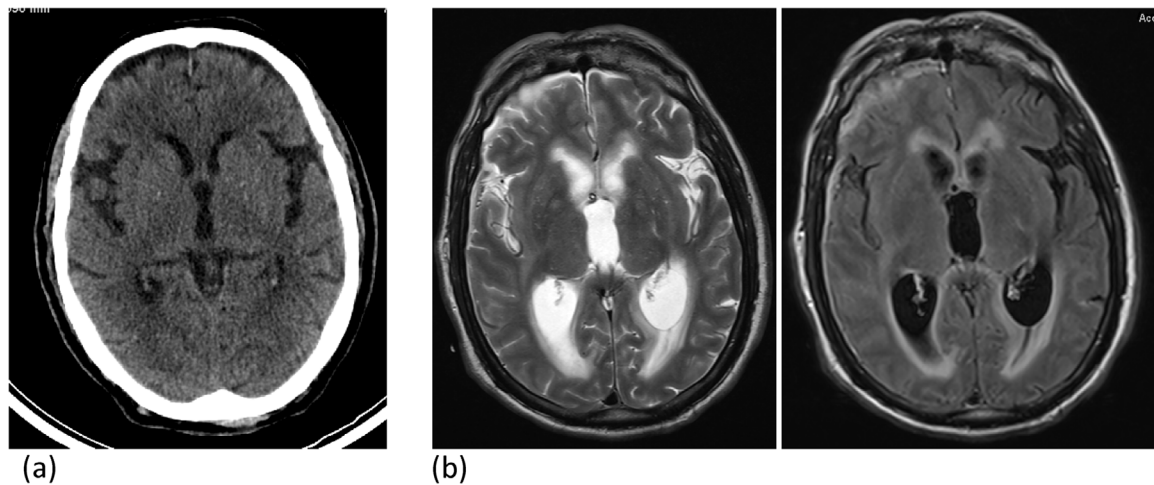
Imaging studies of patient 1. (a) Non-contrast computed tomography showing normal ventricular size. (b) MRI performed 4 days later: T2 and FLAIR: Enlargement of the lateral and third ventricles with periventricular trans-ependymal CSF edema. MRI- magnetic resonance imaging, CSF-Cerebro-spinal fluid.
